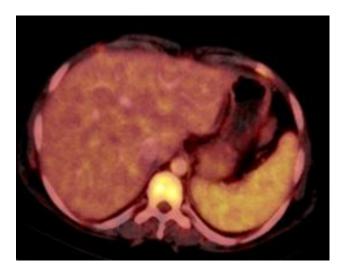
PET CT of abdomen showing increased uptake.
